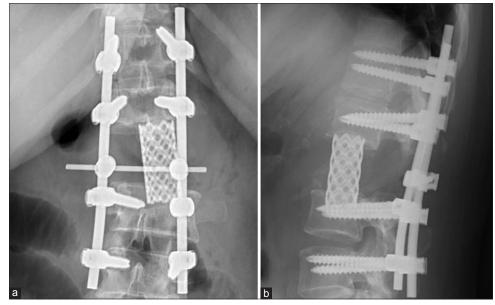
(a and b) X-ray anteroposterior and lateral views of dorsolumbar spine at 20 month followup showing no recurrence of the lesion, and implants *in situ*
